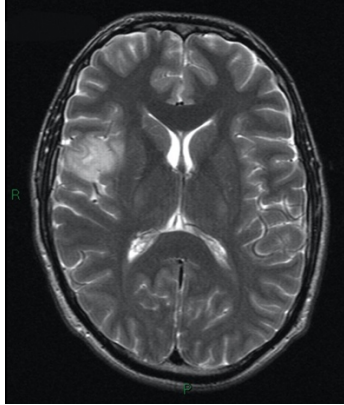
1. Brain axial MRI image
